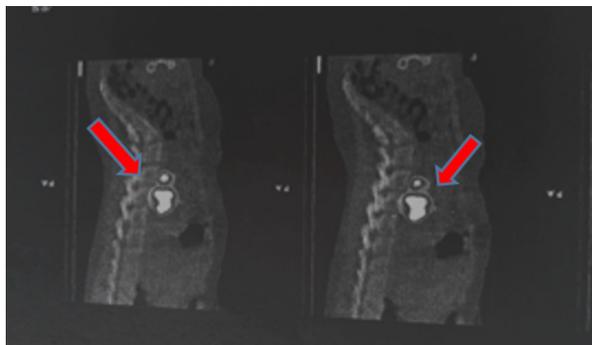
Retroperitoneal paragangliomas on MIBG scintigraphy.
